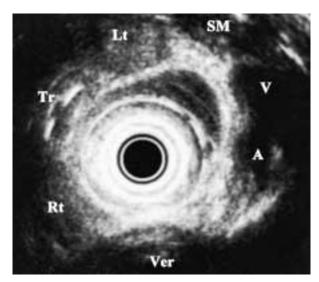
Endoscopic ultrasonography (EUS, 7.5 MHz) showing structures adjacent to the esophagus. Ver: vertebra; Tr: trachea; A: common carotid artery; V: internal jugular vein; SM: sternocleidomastoid muscle; Rt: right lobe of the thyroid; Lt: left lobe of the thyroid.
